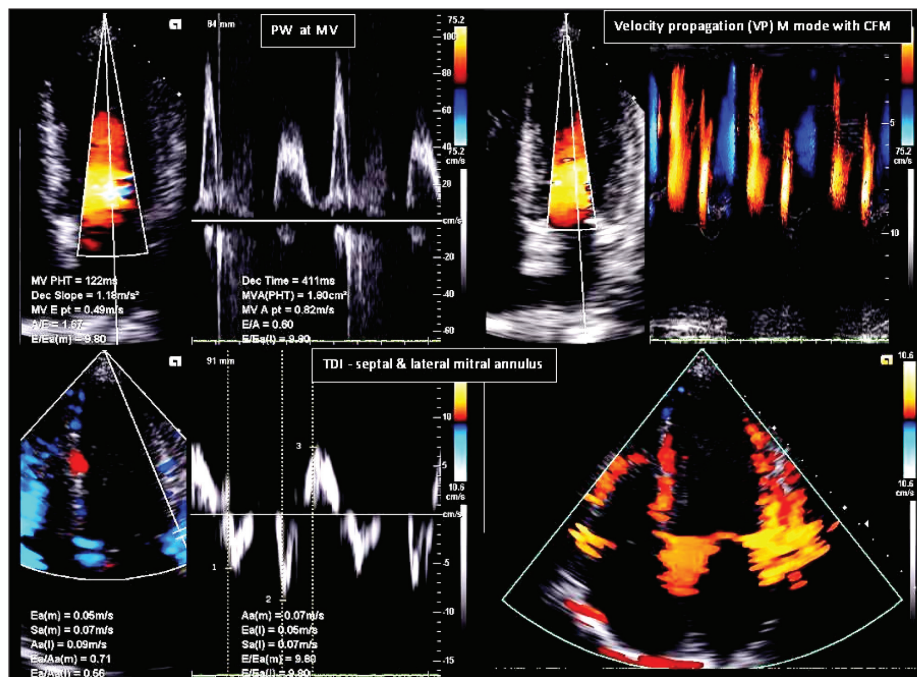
Two dimensional transthoracic echocardiographic evaluation of diastolic dysfunction by pulse wave Doppler (PW) at mitral valve, velocity propagation (VP) by colour 'M' mode and tissue Doppler imaging (TDI) at septal and lateral mitral annulus
